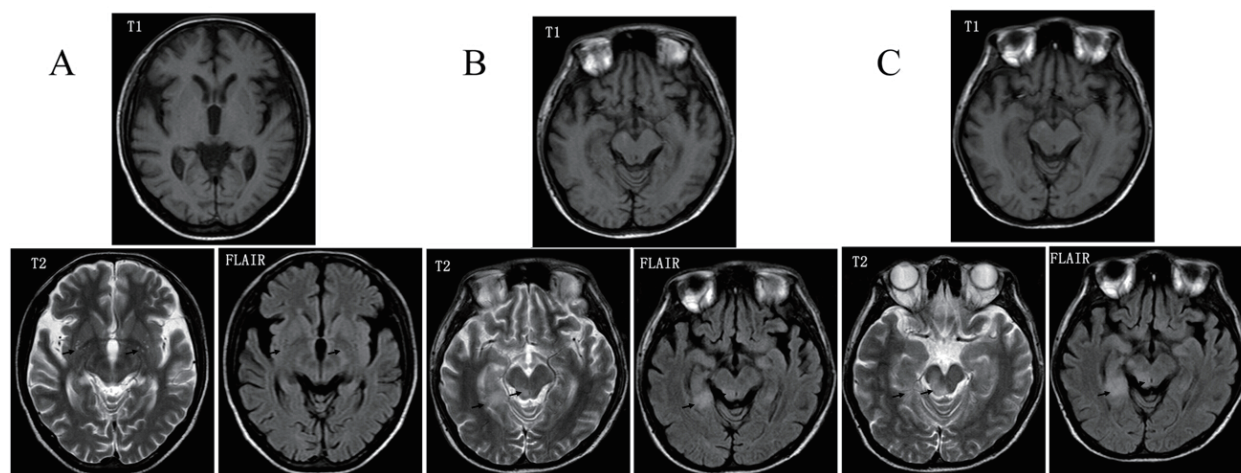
Brain MRI images of two patients. (A) Brain MR imaging revealed both basal ganglia had areas of abnormal signal intensity including hypointensity on T1WI and FLAIR images and hyperintensity on T2WI. Cerebral ventricle dilation and encephalatrophy were also evident. (B) Brain MRI imaging revealed multiple lesions in the cerebrum, cerebellum, and brainstem. Imaging revealed hypointensity in T1WI and hyperintensity in T2WI and FLAIR images. (C) Brain MR imaging revealed multiple lesions in the cerebrum, cerebellum, and brainstem. Imaging revealed hypointensity in T1WI and hyperintensity in T2WI and FLAIR images. There were no significant changes in comparison to image findings in B.
